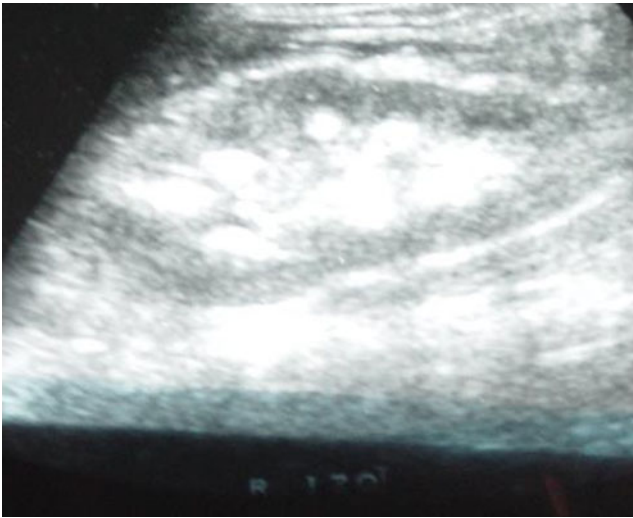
Ultrasonography at 2 months of life
